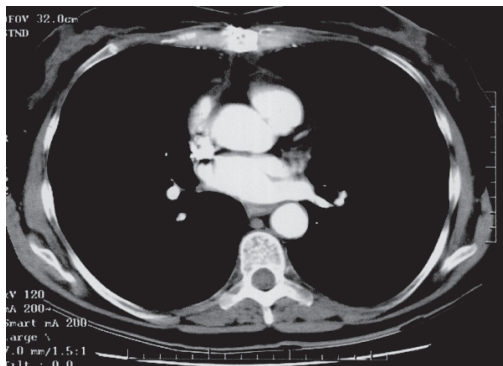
Cardiac mass on CT scan after chemotherapy.
